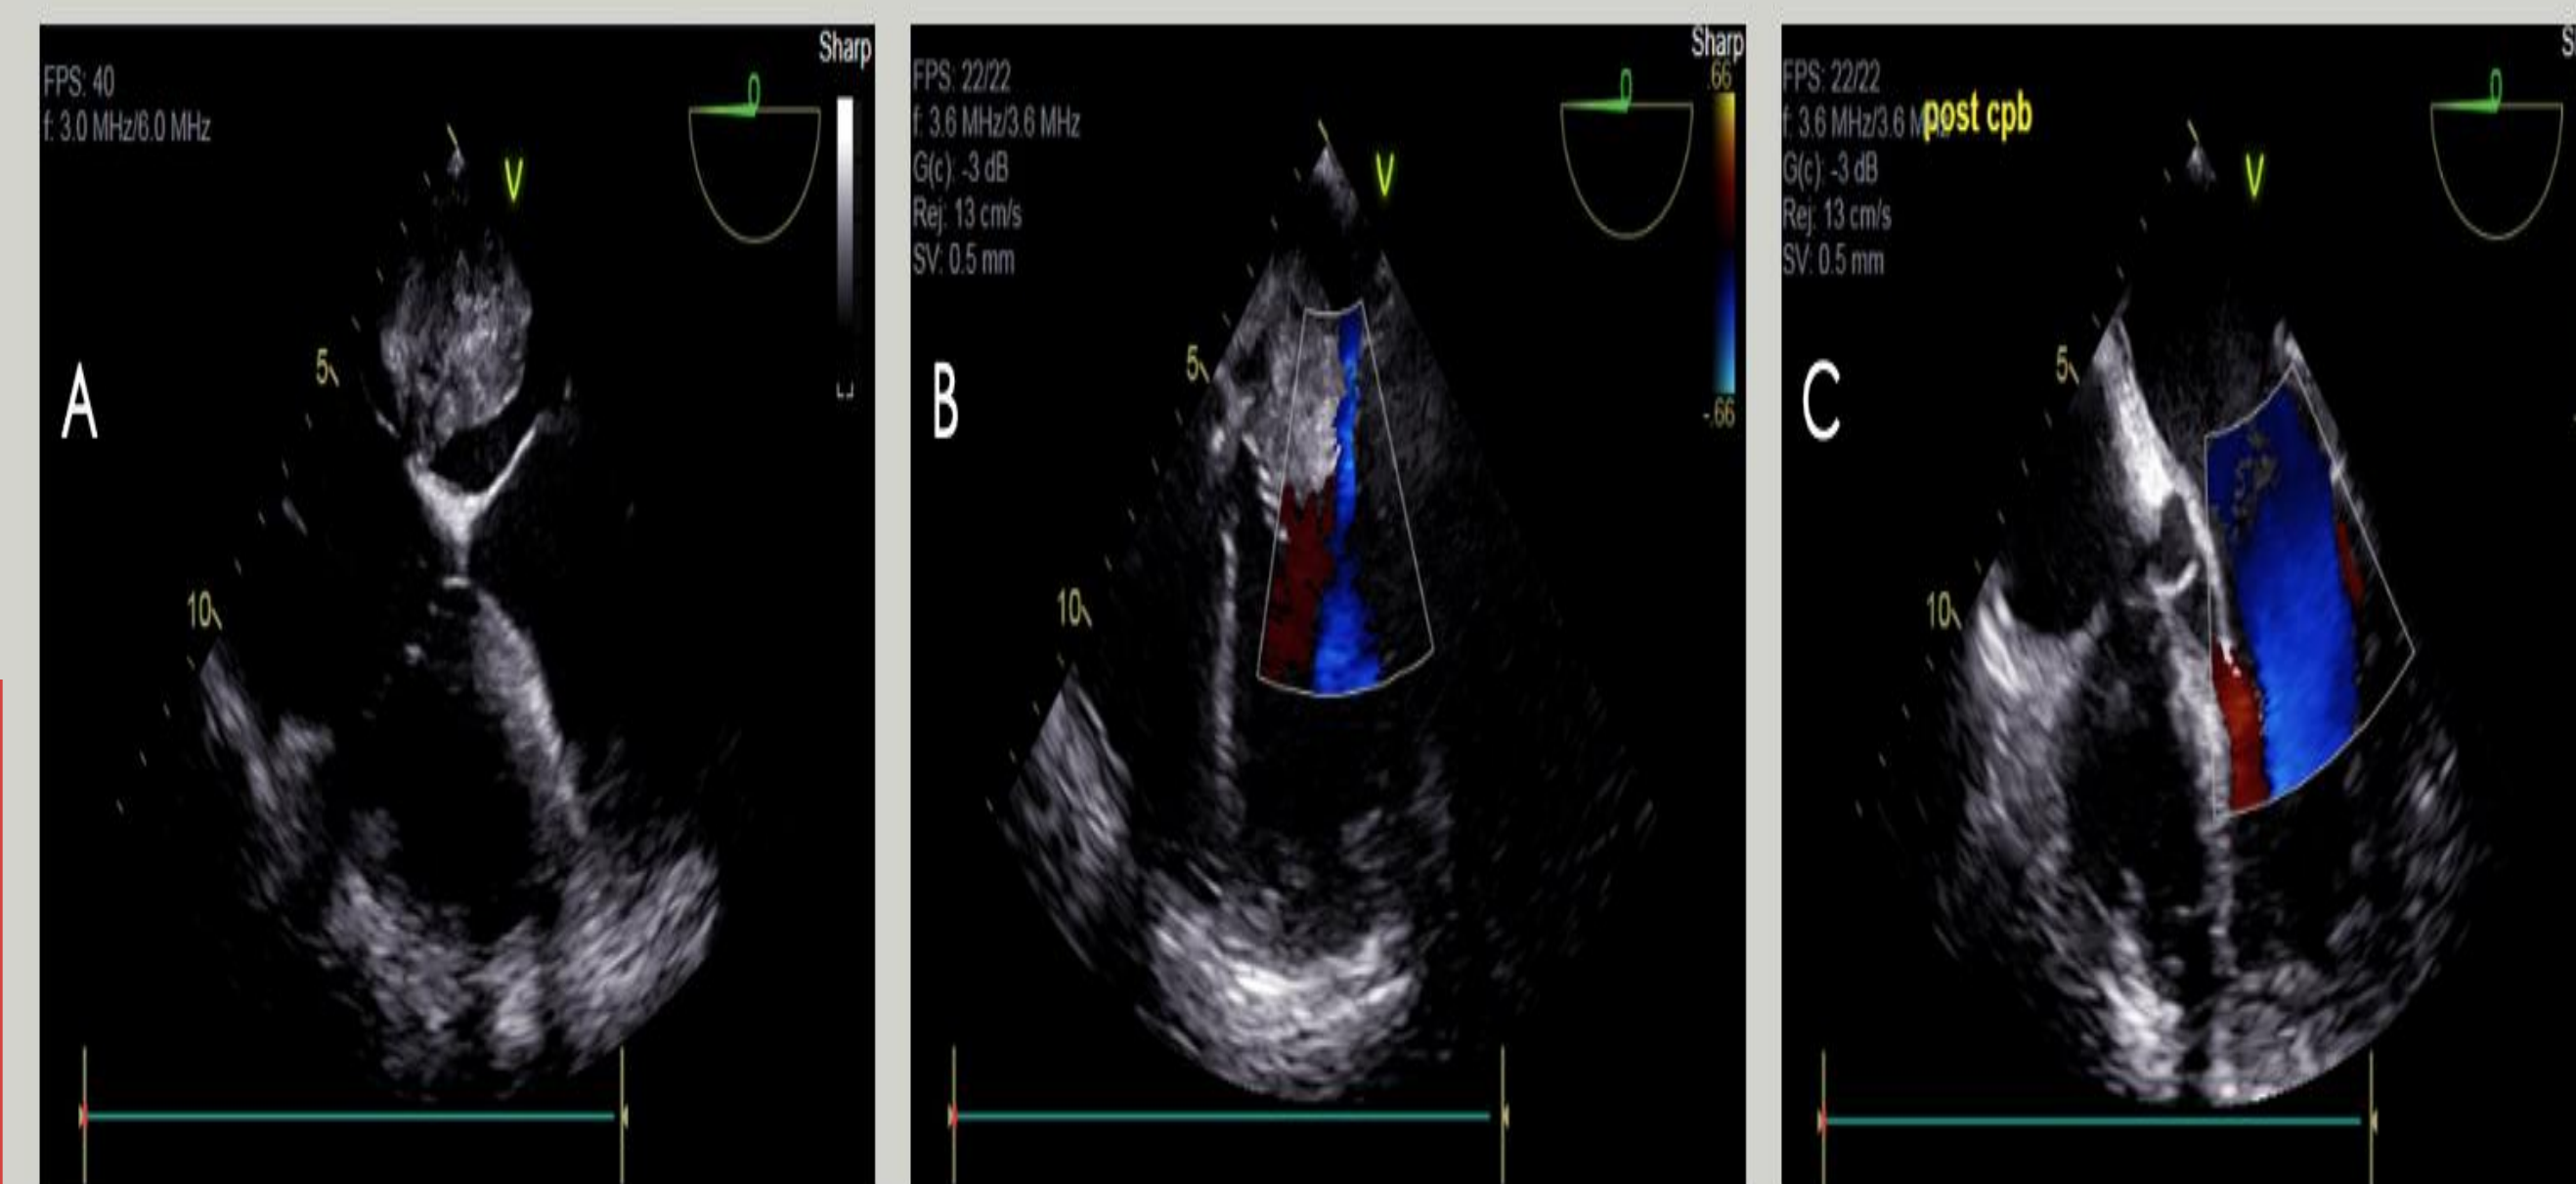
Intraoperative transesophageal echocardiography demonstrating myxoma in left atrium (5A) with obstruction of mitral inflow during diastole (5B), with unimpeded mitral inflow post surgical resection and removal from cardiopulmonary bypass (5C).
